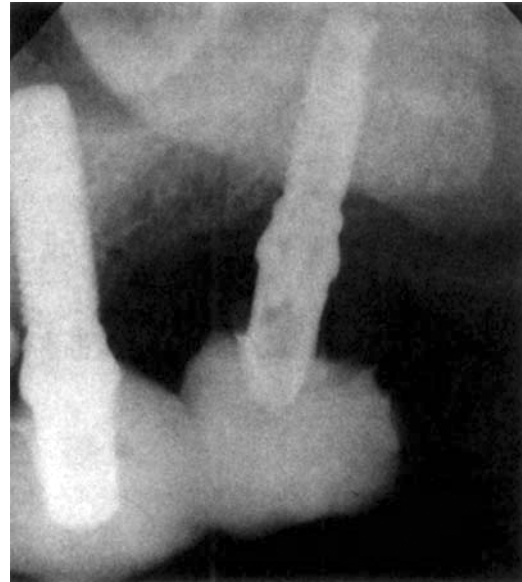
Periapical radiograph after a 6-month loading time: the implant is radiographically surrounded by mineralized tissues, and there is a minimal bone resorption.
